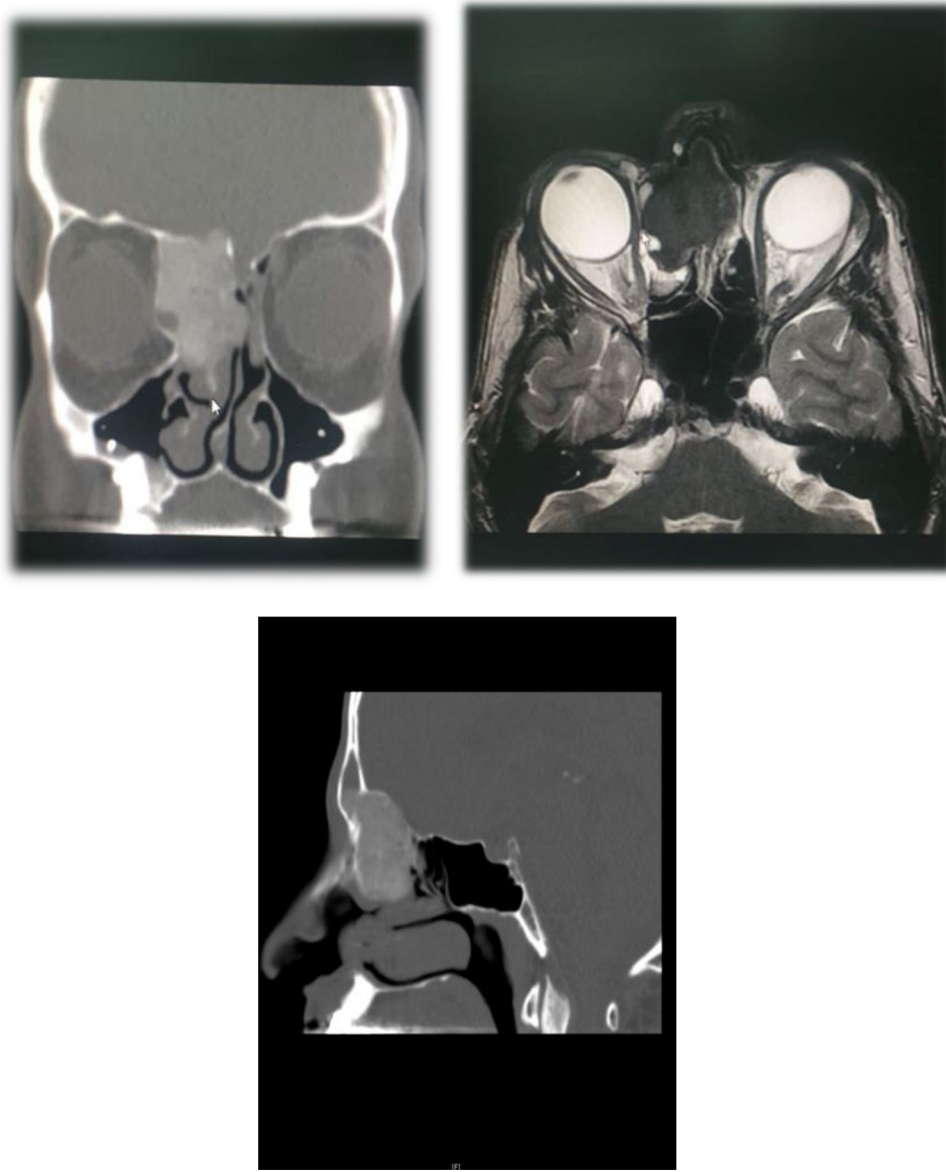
Paranasal coronal, axial and sagittal CT scan shows right ethmoid sinus and nasal cavity tumor.
